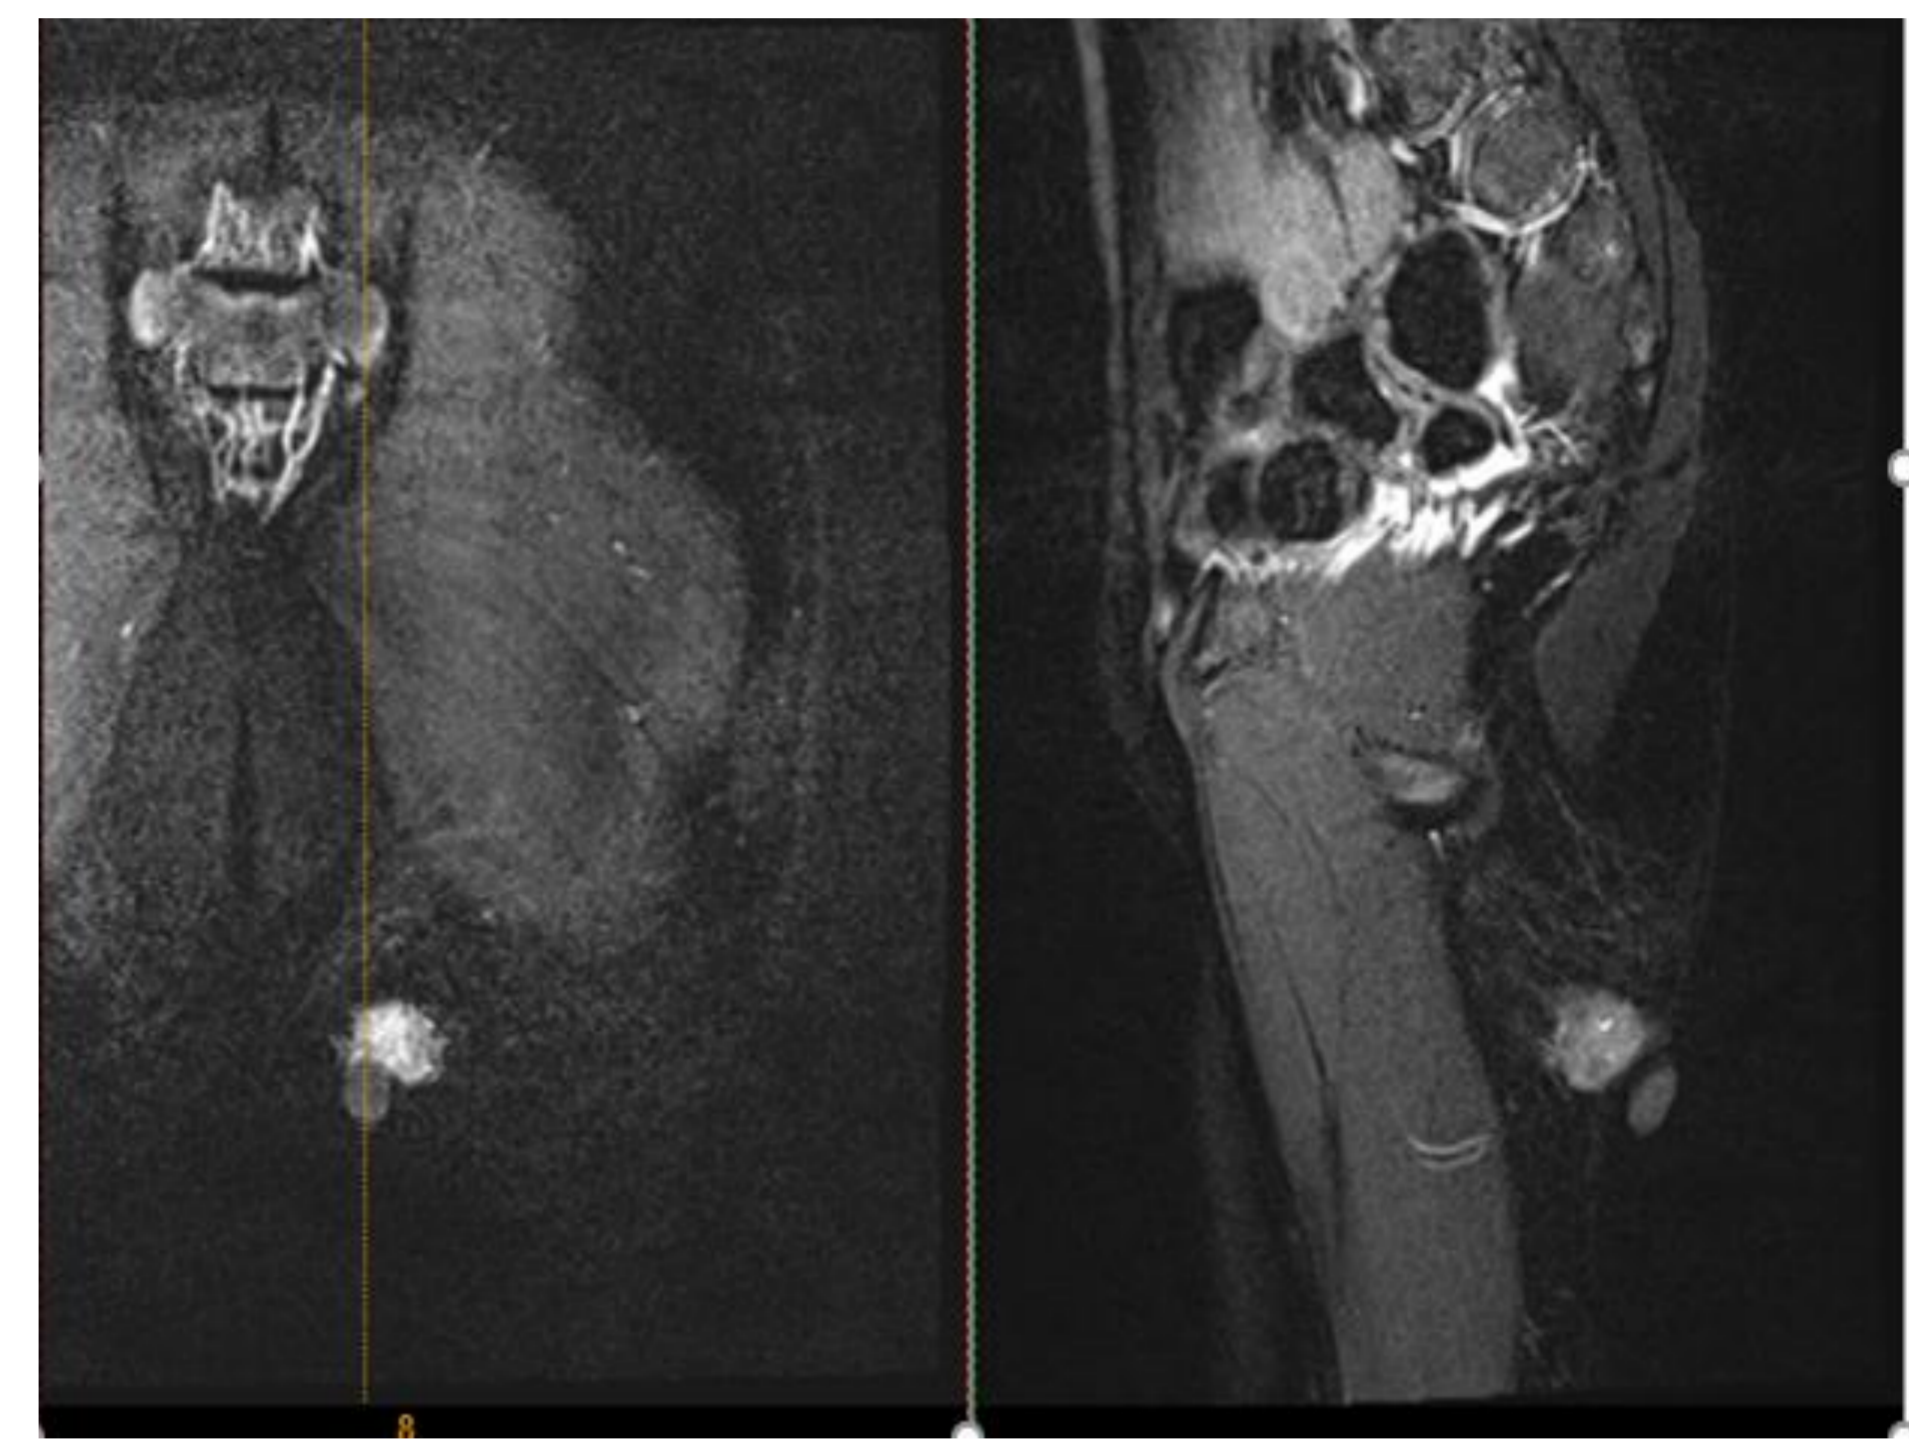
MRI of left gluteal mass
